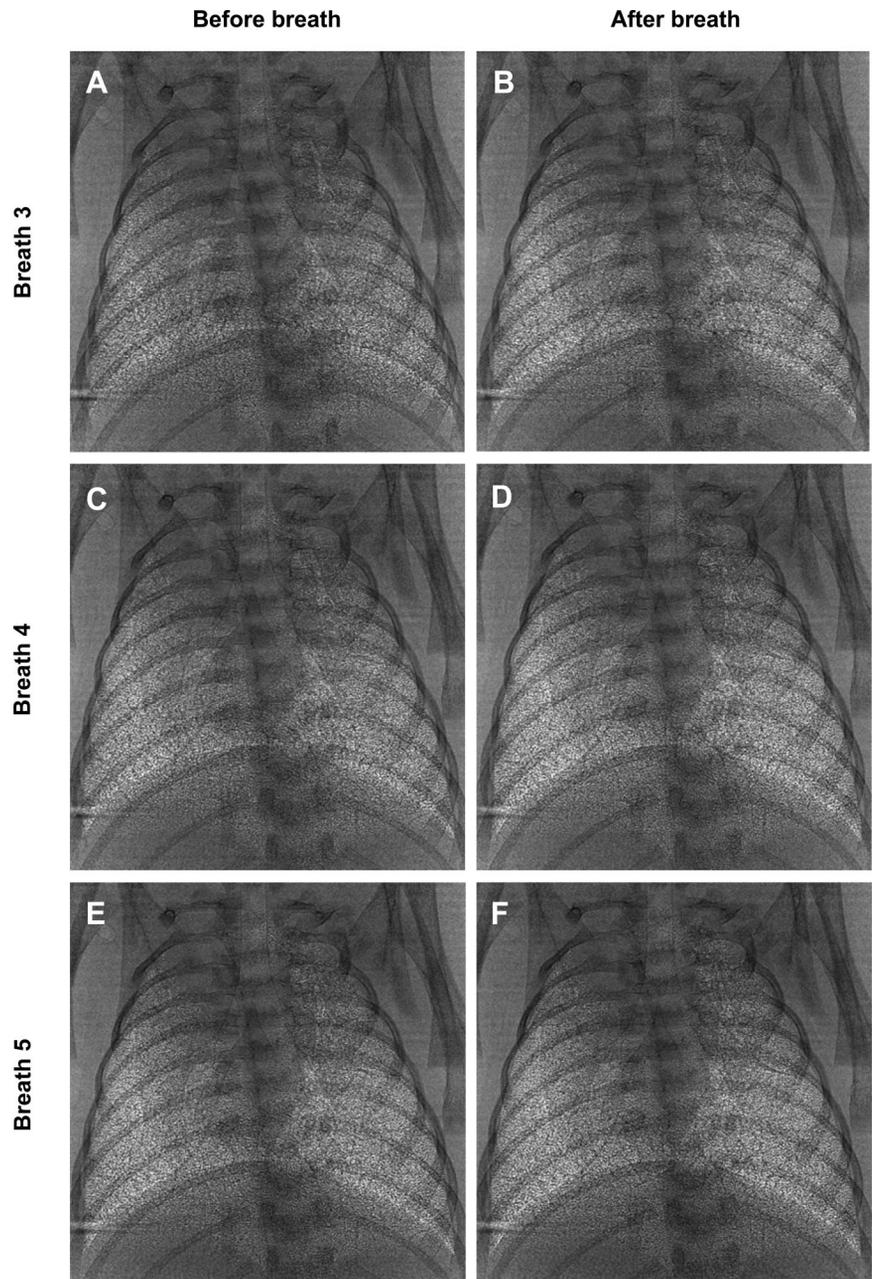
Phase-contrast X-ray images (A–F) were acquired at the times indicated by the arrows (a–f) in Fig. 1. Images were acquired immediately before (A, C, and E) and after (B, D, and D) the 3rd, 4th, and 5th breaths after birth, respectively. In A, only the medial/basal lobes of the lung are partially aerated, with no aeration in the apical lobes, and no definition of the rostral margin of the diaphragm is apparent. Image in B was acquired 1.6 s after that in A and immediately followed the 3rd breath. This single breath resulted in aeration of the medial and basal lobes of the lung, thereby providing definition to the rostral margin of the diaphragm, as well as some aeration of the apical lobes. After the 5th breath (F), the lung is relatively well aerated. This process can be observed in real time by examining Supplemental Movie 1.
